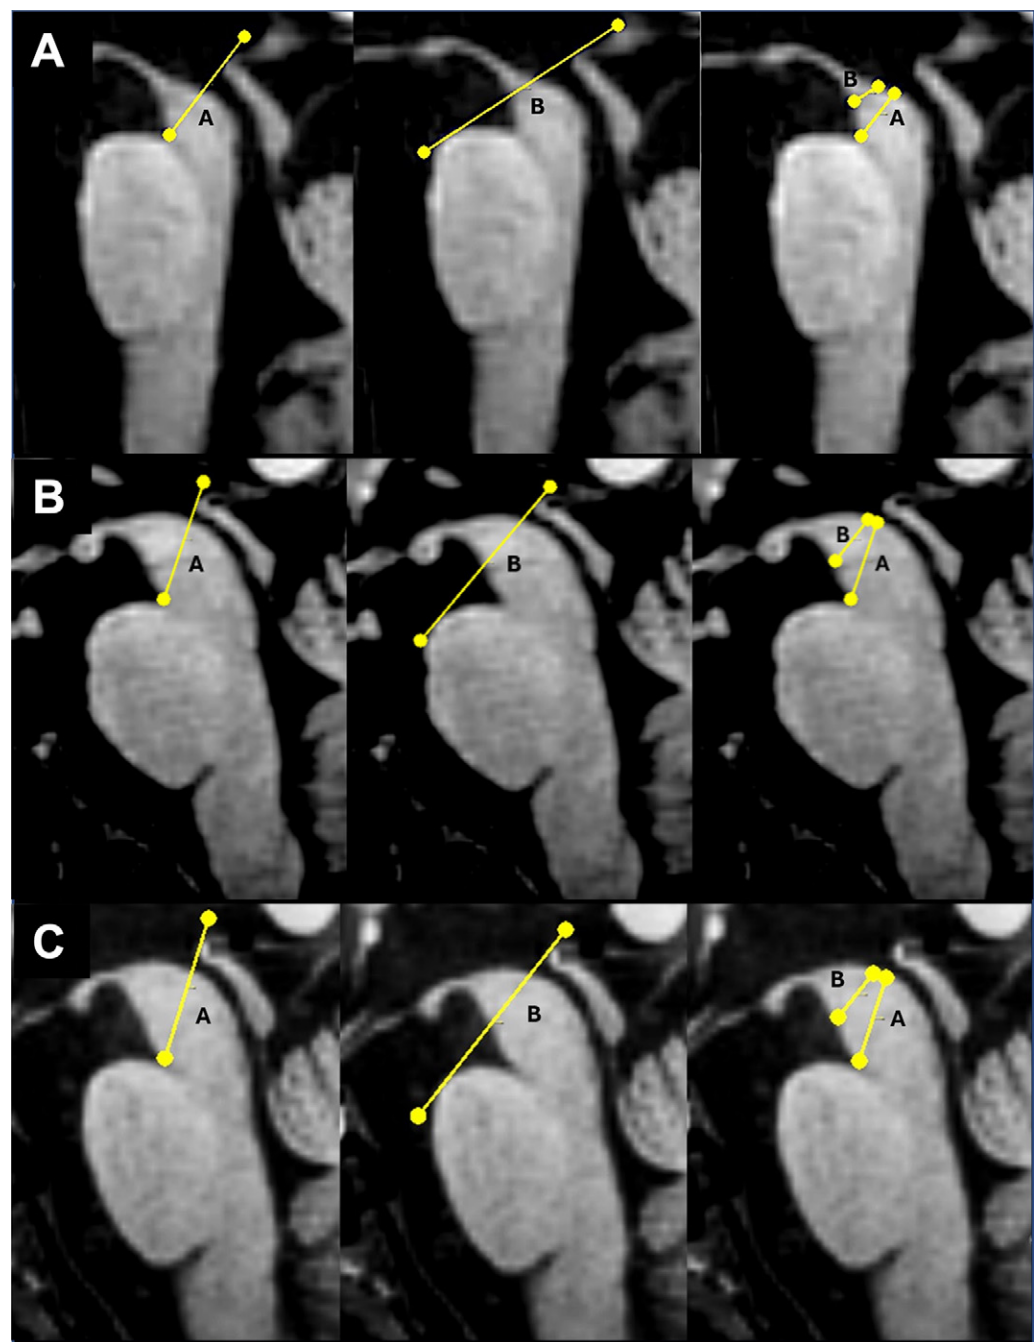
Linear brainstem measurements were manually performed on the midsagittal section of three-dimensional T1-weighted volumetric MRI examinations. Images in a (A) 74-year-old male participant with progressive supranuclear palsy (PSP)–Richardson syndrome (upper row), (B) 62-year-old female participant with Parkinson disease (PD) (middle row), and (C) 63-year-old healthy male participant (bottom row). In the leftmost panels, a line termed “A” was traced from the anterior notch of the ponto-mesencephalic junction to the posterior commissure; the distance between the ponto-mesencephalic junction and the midbrain border was measured. In the middle panels, a second line termed “B” was traced tangent to both the superior border of the pons and the posterior commissure, and the midbrain width along this line was measured. For clarity, the two midbrain measurements (A and B) investigated in this study are shown in the rightmost panels. These two measures were averaged, $(A + B)/2$, to calculate the dual-line midbrain PSP index (DMPI). The DMPI value was 5.15 in the participant with PSP (A), 10.15 in the participant with PD (B), and 11.10 in the control participant (C).
